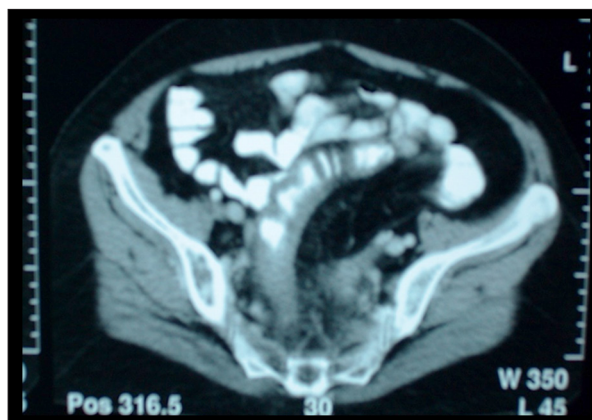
Abdominal-pelvic computed tomography scan with intravenous and oral contrast showing partial thickening of the sigmoid with pseudo-obstruction of the lumen. Possibly a sequela to diverticular disease, however neoplastic disease cannot be ruled out.
